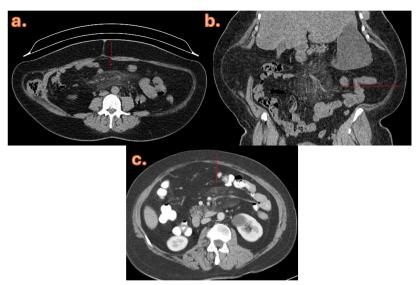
a:-Mesenteric fat stranding with lymph nodes exhibiting a capsular appearance and surrounding halo in a female patient presenting with abdominal pain, observed in the midline. b-c: Abdominal CT images in axial and coronal planes, performed due to a history of nephrolithiasis, demonstrating marked mesenteric fat stranding and mild mass effect on the adjacent bowel loops.
